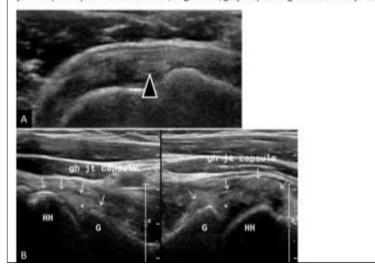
Patient came with complains restriction of movement of the shoulder joint, ultrasonography reveals thickened coracohumeral ligament(between the calipers), long head of biceps tendon(arrow head).8B: Gray scale ultrasonography of both shoulder joints to the right is normal glenohumeral joint capsule(white arrows), to the left thickened glenohumeral joint capsule.(HH=Humeral head;G=glenoid; gh jt capsule=glenohumeral joint capsule)
